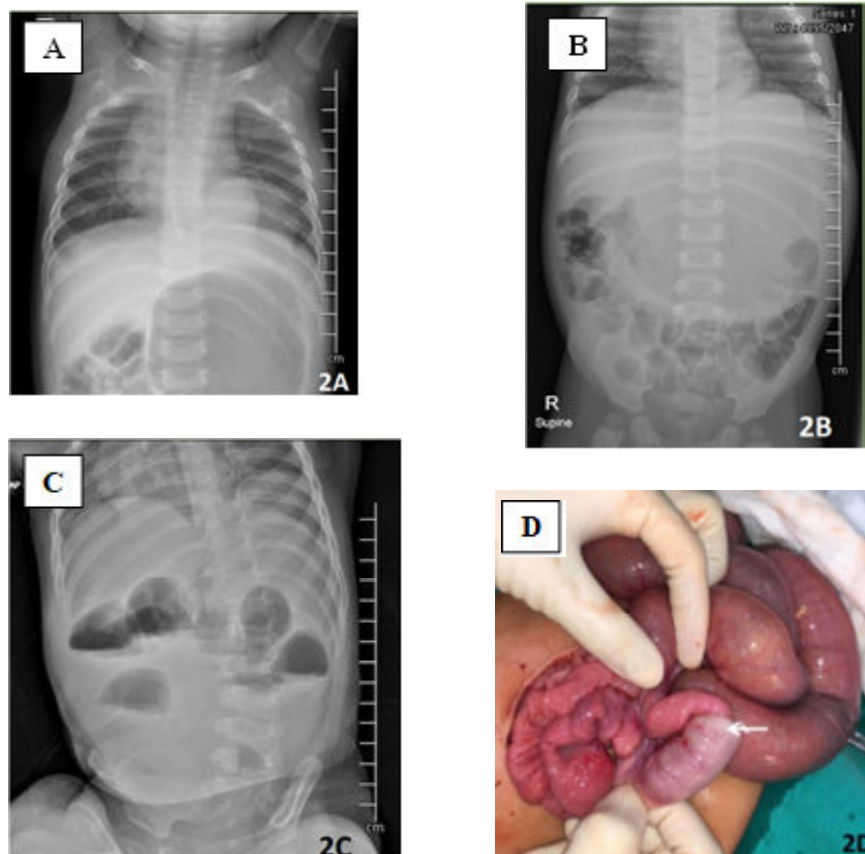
(A) Chest X-ray with the presence of soft tissue density at the posterior aspect of the left Hemithorax; (B) Plain abdomen X-ray with marked dilatation of stomach; (C) Plain abdomen X-ray with gut obstruction; and (D) Jejunoileal intussusception (arrow).
